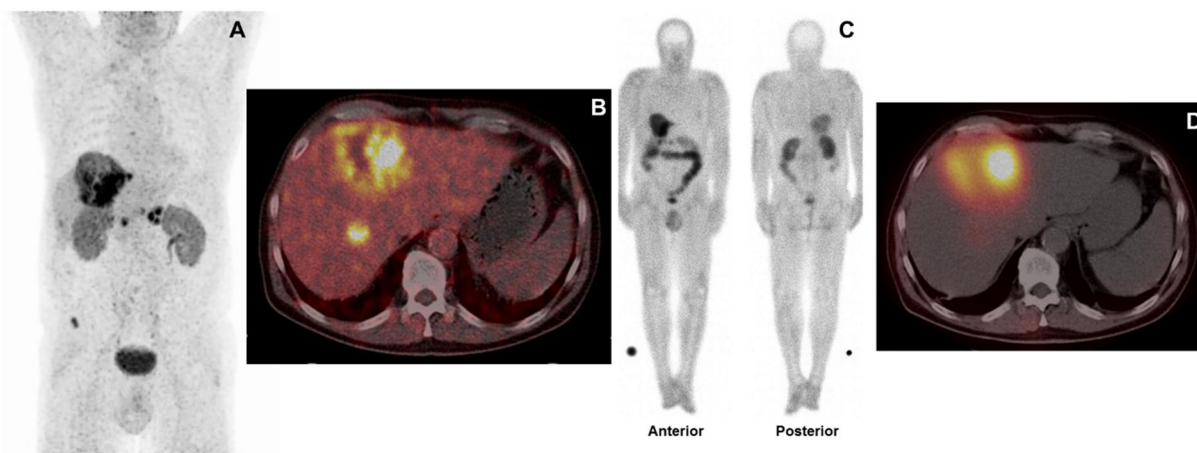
Pt. 4 had adenocarcinoma of the pancreatic body and hepatic, peri-pancreatic lymph node, and osseous metastases, which demonstrated a high FAP-expression on ^{68}Ga -FAP-2286 PET/CT (A, maximum intensity projection image, B, transverse fused PET/CT image). Significant uptake and late retention of ^{177}Lu -FAP-2286 was noted in the liver metastases on post-therapeutic whole-body scintigraphy in anterior and posterior view at 48 hours post injection (C), and the transverse fused SPECT/CT image (D) and. Note: due to the low resolution of ^{177}Lu for imaging as compared to PET/CT using ^{68}Ga , not all tumor sites seen on ^{68}Ga -FAP-2286 PET/CT are apparent on ^{177}Lu -FAP-2286 images.
